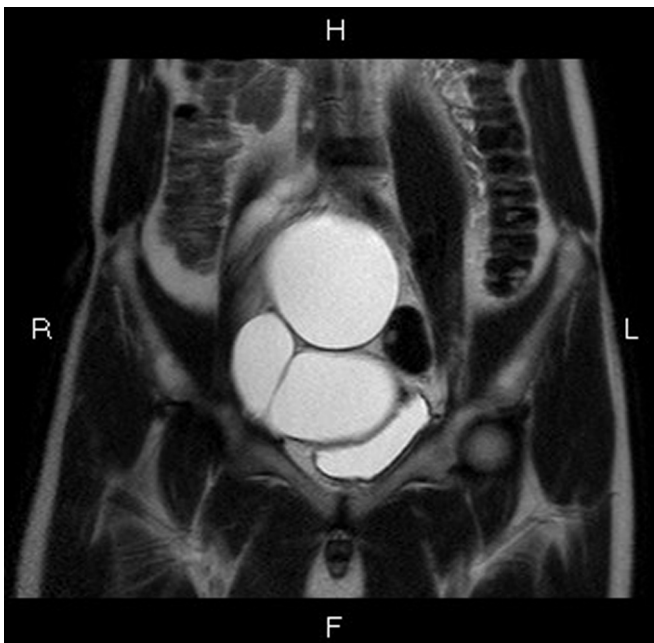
MRI of pelvis showed a cystic lesion within pelvic cavity which compressed the right border of bladder.
